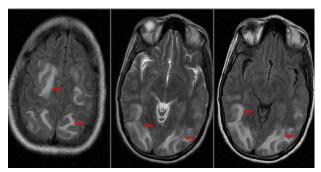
Brain MRI showing symmetrical cerebral vasogenic edema bilaterally involving the occipital, parietal and posterior parts of frontal lobes (Red Arrows), picture highly indicative of PRES.
